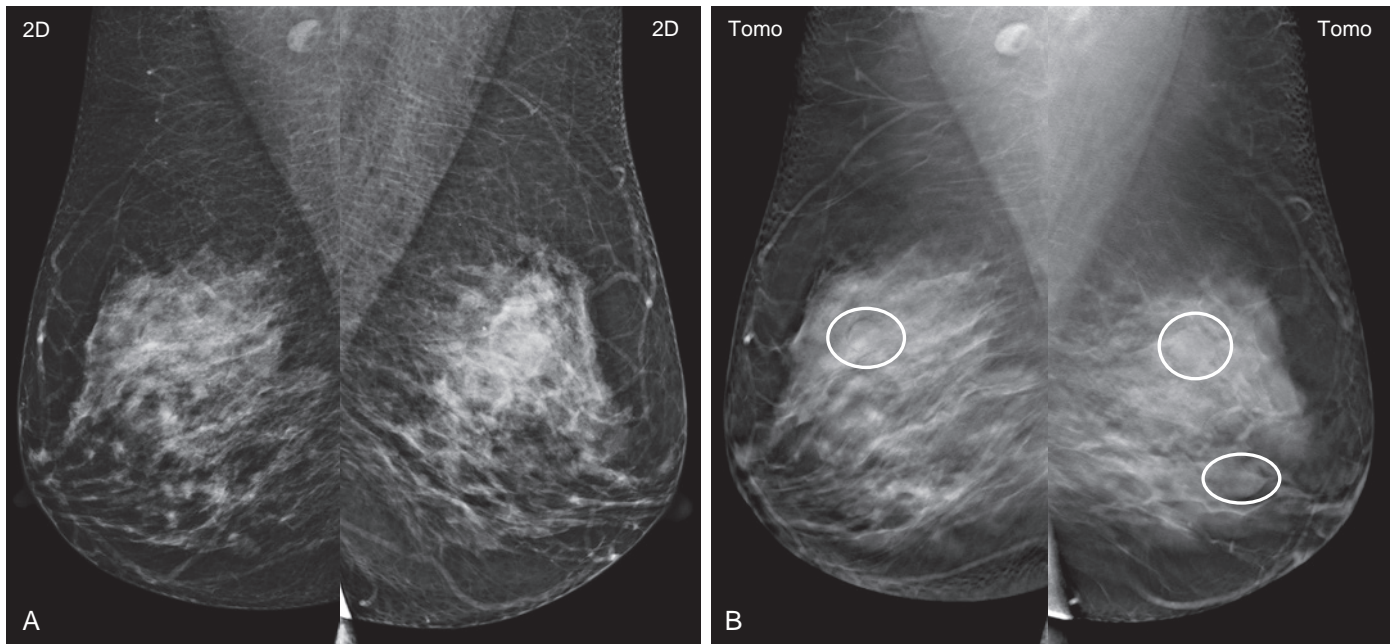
Multiple bilateral cysts. A 58-year-old woman presented for screening. (A) 2D MLO views demonstrate extremely dense tissue. (B) Selected tomosynthesis images reveal multiple bilateral circumscribed masses (*ovals*), which are not well delineated on 2D imaging alone. These benign-appearing masses on tomosynthesis were confirmed to be multiple benign cysts by ultrasound performed for dense breast screening ultrasound (not shown), BI-RADS 2.
